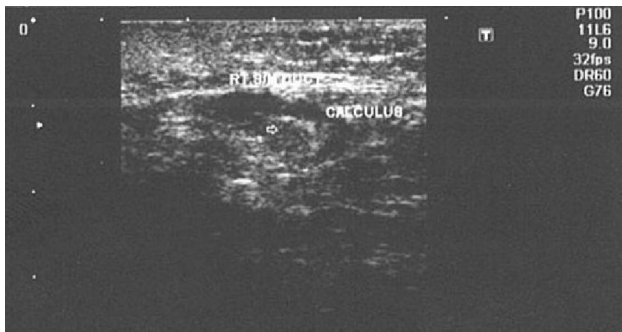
Ultrasound in longitudinal (LS) axis of right submandibular region showing dilated Wharton's duct with echorefective calculus (marked by arrow) in medial portion of remains of Wharton's duct. (Previous history of removal of right submandibular salivary gland).
